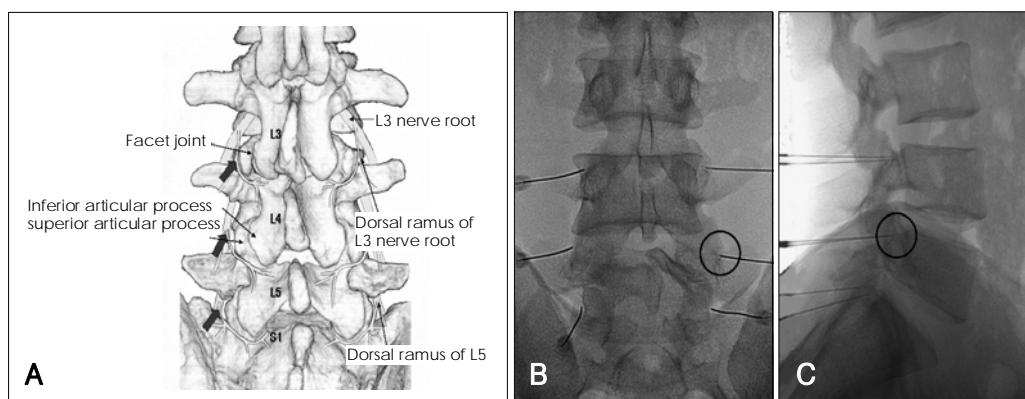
Target points for dorsal ramus block. A: Picture showing the target point of dorsal ramus block (large arrows), the angle between transverse process and superior articular process. B, C: Radiographs showing needles injected to the target points of dorsal ramus block for bilateral L3, 4, 5 dorsal rami. Black circle indicating the target point of L4 dorsal ramus block (A: Anteroposterior view. B: Lateral view).
